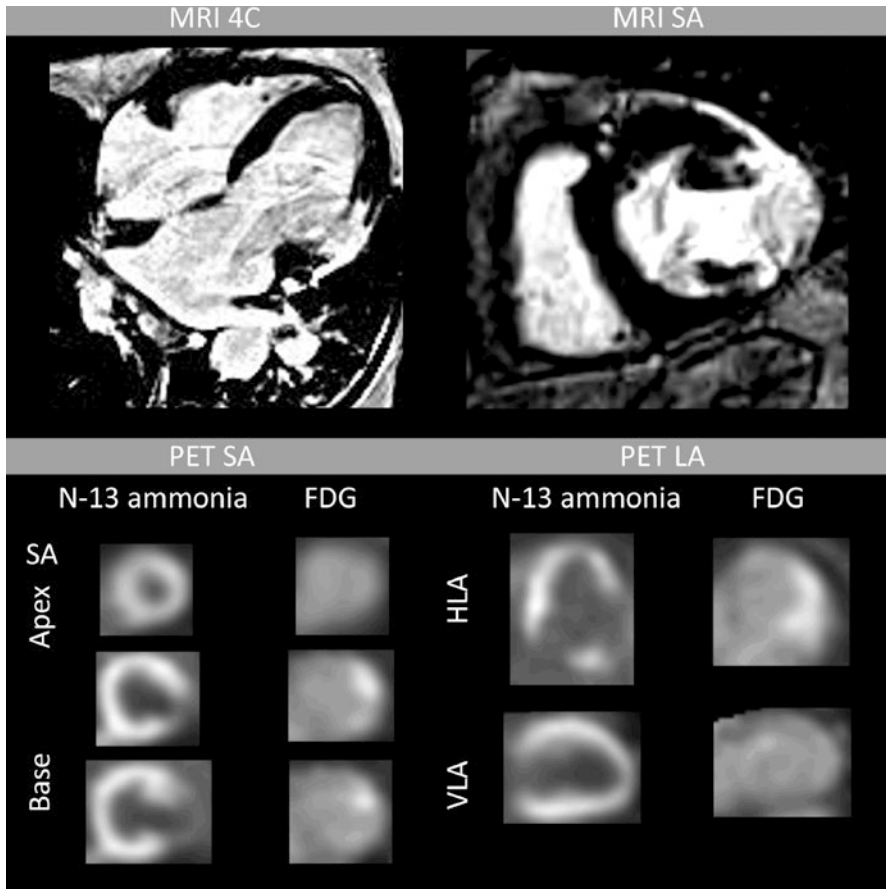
Top: MRI 4-chamber (left) and basal short-axis views (right) showing an aneurysmal basal lateral segment with transmurial delayed enhancement denoting scar. Bottom: N-13 ammonia and FDG-PET showing decreased perfusion but intense FDG uptake in the corresponding segment, indicating active inflammation as opposed to scar
